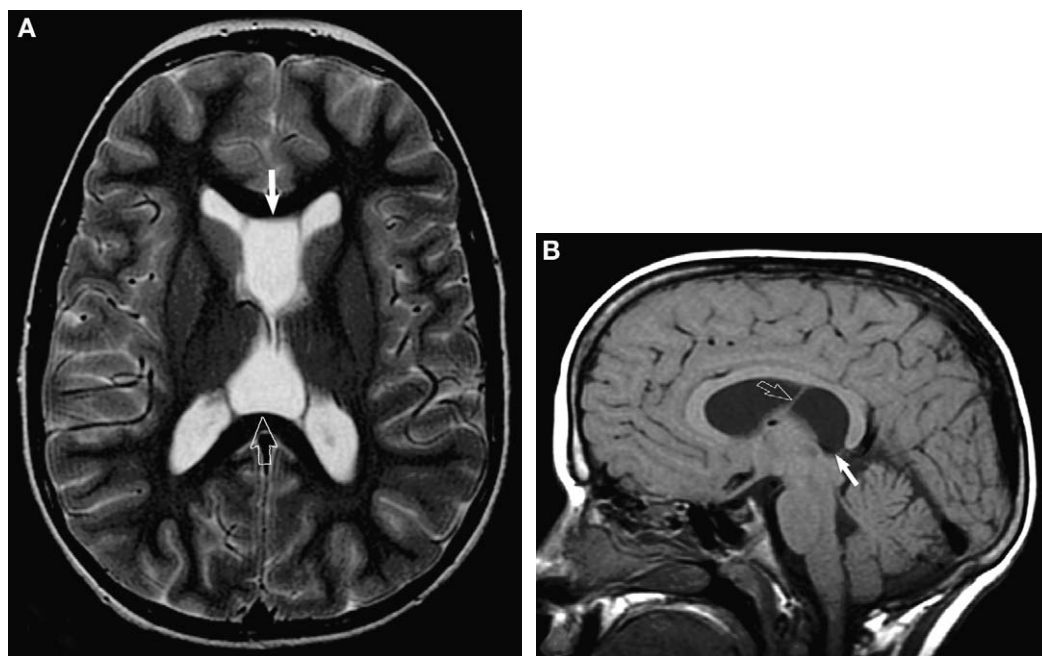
Cavum septum pellucidum (CVP) and cavum velum interpositum (CVI). (A) Axial T2-weighted image demonstrates the CVP anteriorly (arrow) and CVI posteriorly (open arrow). (B) Sagittal T1-weighted image demonstrates anterior and superior displacement of the fornix (open arrow) distinguishing the CVI from the cavum vergae. Note characteristic inferior displacement of the internal cerebral veins (arrow).
